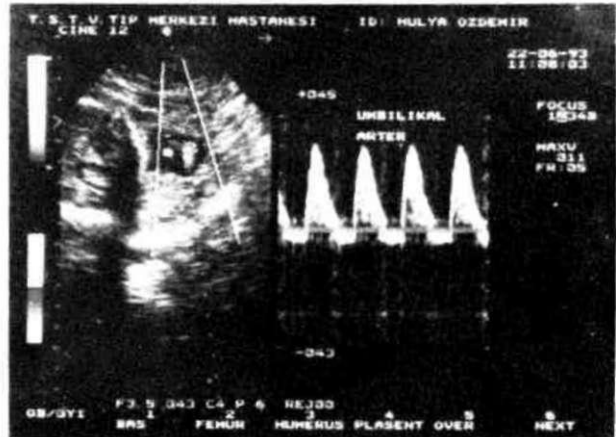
Reversed end diastolic umbilical artery flow in color Doppler velocimetry.
